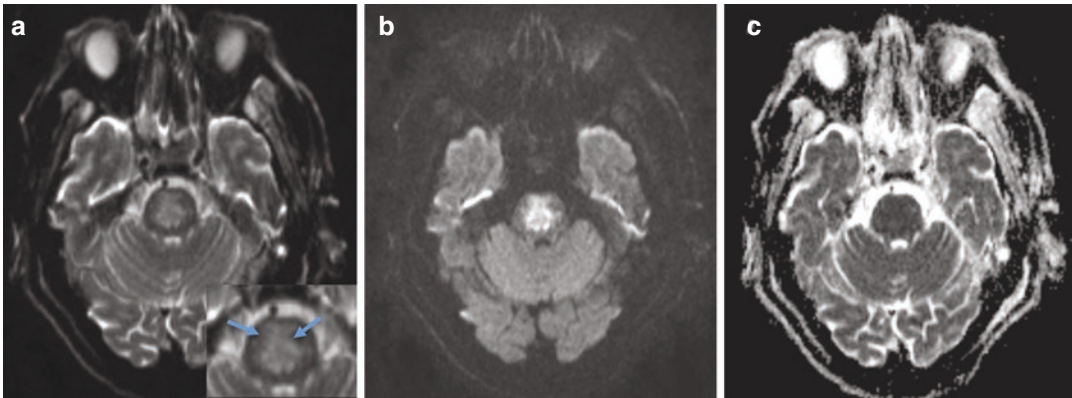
Central pontine myelinolysis in the pons with restricted diffusion (b: DWI, c: ADC map). The T2-weighted image shows a rather horizontal orientation, a peripheral rim (a), and sparing of the pyramidal tracts in the cerebral peduncles (a: inset: arrows)
